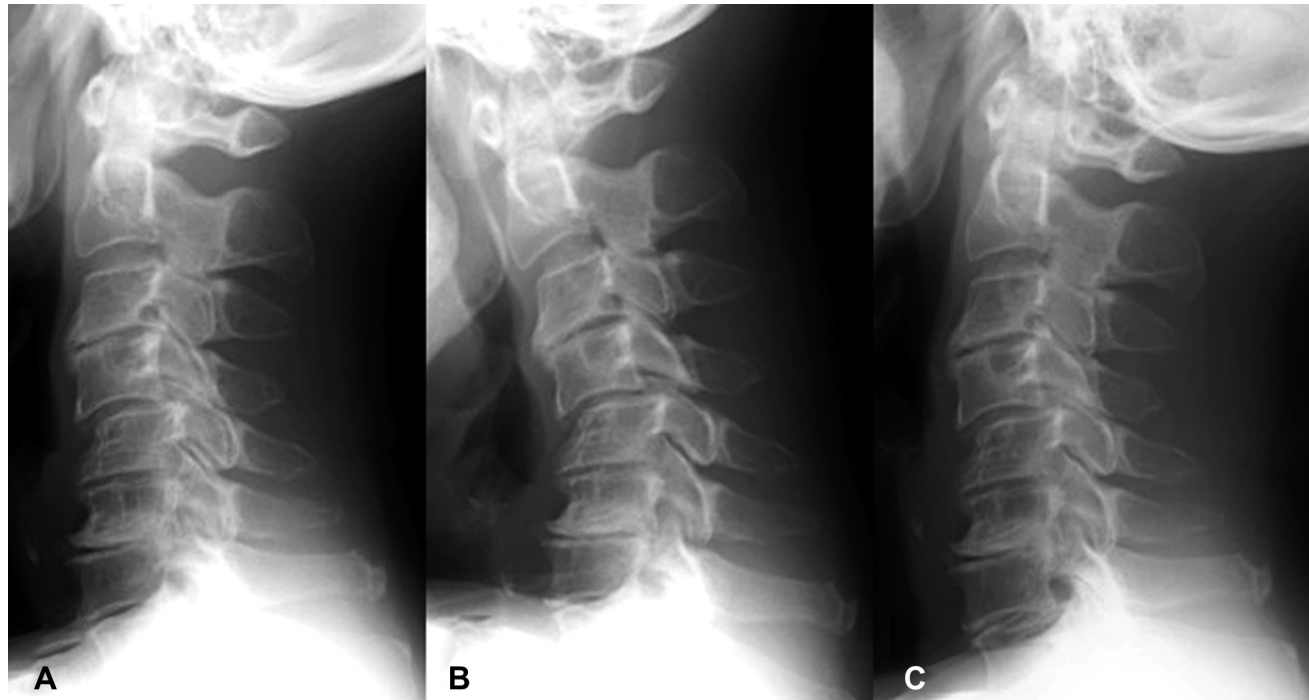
Preoperative radiographs of the cervical spine. Sagittal alignment is kyphosis and C4/C5 slippage is increased by flexion posture. (A) X-P, lateral view, neutral posture; (B) X-P, lateral view, flexion posture; (C) X-P, lateral view, extension posture.
